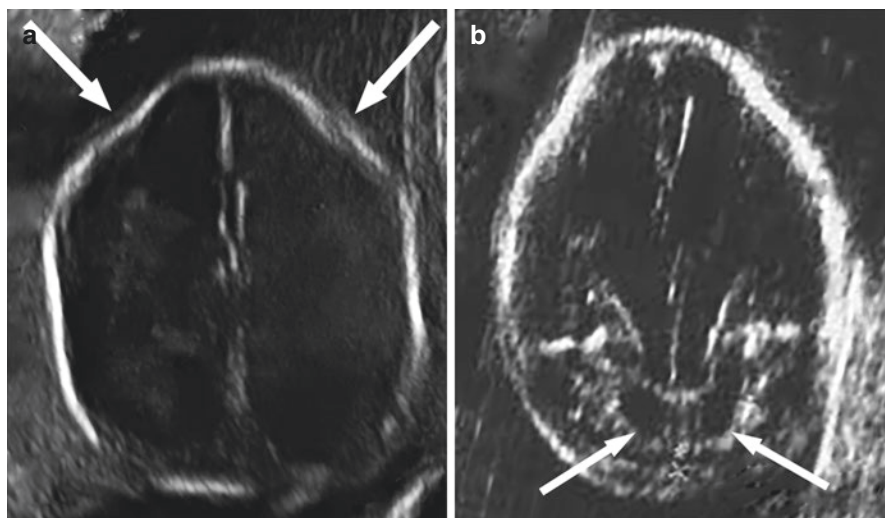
Antenatal cranial ultrasonography depicting the lemon sign (a) and banana sign (b) in a fetus with CM-II
